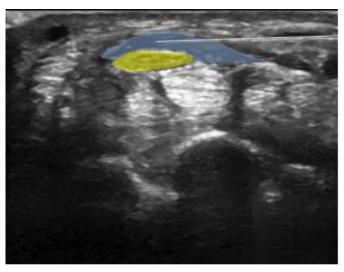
Hydrodissection-ultrasound guide (cross-section)¹⁰
